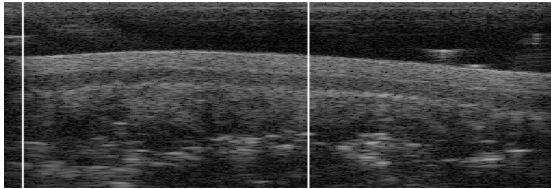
Longitudinal ultrasound image of ganglionic tissue layers
